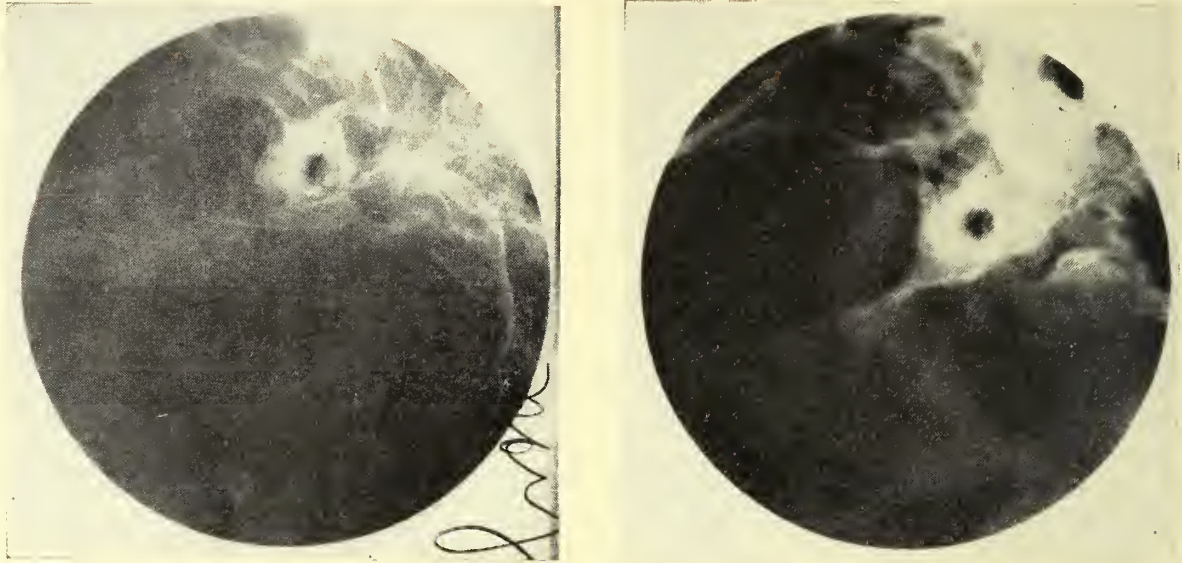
An x-ray of a normally pneumatized mastoid in a 4-year-old girl.
